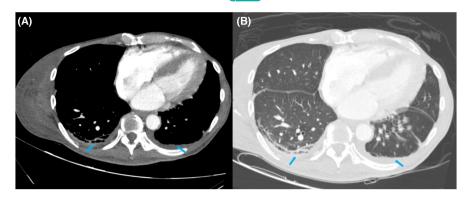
CT thorax with IV contrast (A) mediastinal and (B) lung windows, showing bilateral pleural effusion (Blue arrows) and right-sided pleural enhancement suggestive of empyema (red arrow). Bibasilar atelectatic changes were also noted (yellow arrows).
